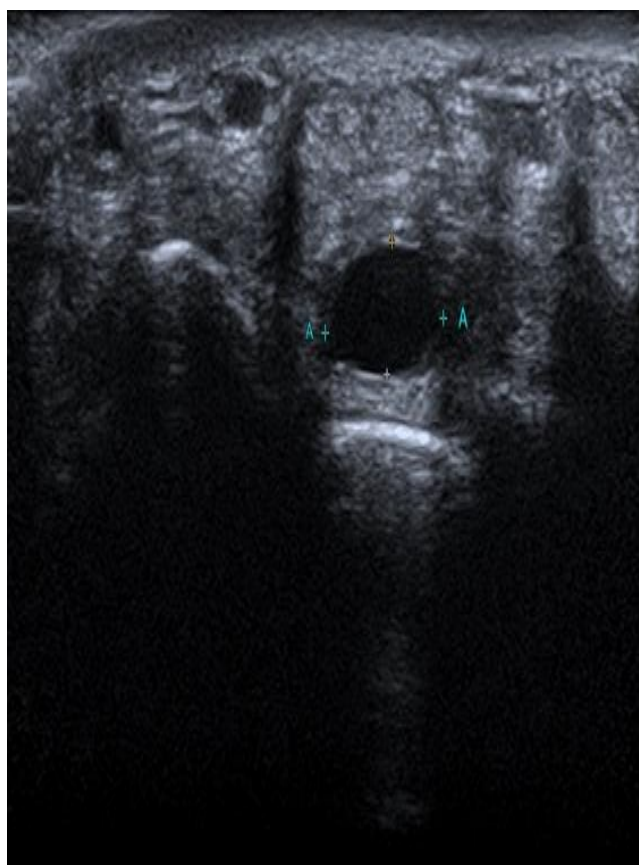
and 2): A 25 years old male patient complaining from dorsal wrist pain Figure 1 shows Ultrasound images that revealed ganglion cyst related to the dorsum of the wrist between capitate and lunate. Figure 2 MRI shows Same findings noted by Ultrasound.
